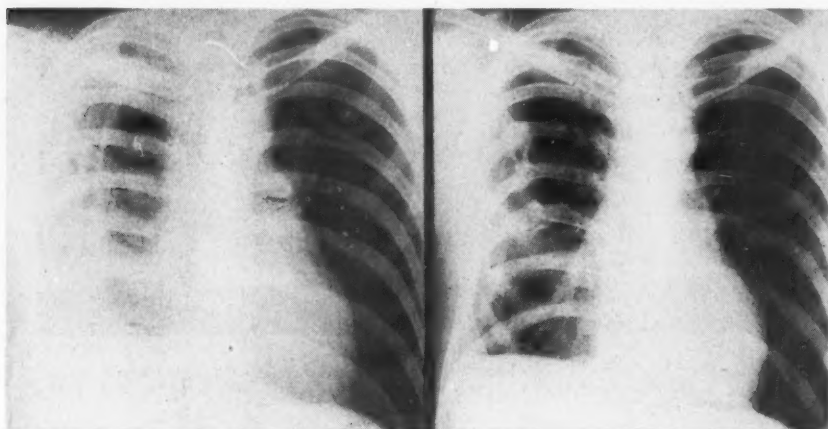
Case 7: Additional roentgenograms demonstrating gradual obliteration of previous pneumothorax by reexpansion of lung, but also by shift of mediastinum. By February 16, through contraction of pleural fibrous tissue, heart has assumed a midposition in the chest.
